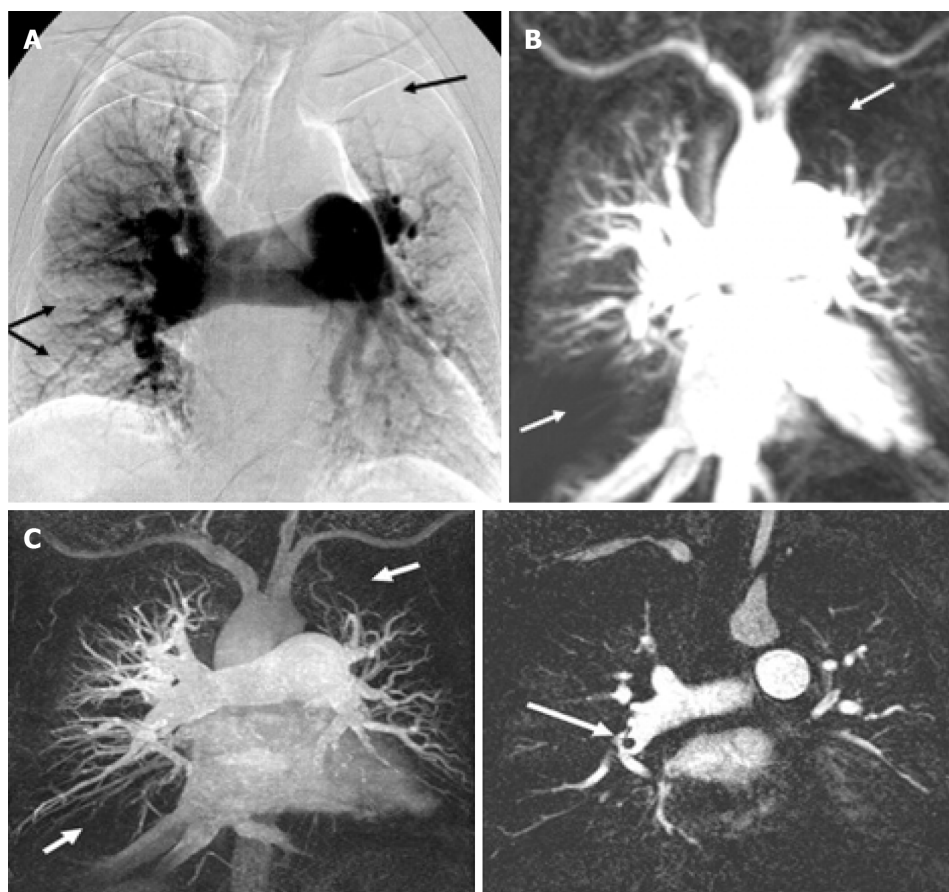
Comparing digital subtraction angiography, pulmonary perfusion magnetic resonance imaging and magnetic resonance angiography for identifying perfusion defects in chronic thromboembolic pulmonary hypertension patient. A: Digital subtraction angiography showing perfusion defects (arrows) in left upper lobe and right lower lobe due to thromboembolic occlusion; B: Magnetic resonance imaging perfusion image at peak enhancement showing hypo-intense perfusion defects at same locations; C: Magnetic resonance angiogram of the same patient demonstrating dark thromboembolic material in the right pulmonary artery corresponding to perfusion defects at the same location. Citation: Nikolaou K, Schoenberg SO, Attenberger U, Scheidler J, Dietrich O, Kuehn B, Rosa F, Huber A, Leuchte H, Baumgartner R, Behr J, Reiser MF. Pulmonary arterial hypertension: diagnosis with fast perfusion MR imaging and high-spatial-resolution MR angiography—preliminary experience. *Radiology* 2005; 236: 694-703 [PMID: 15994997 DOI: 10.1148/radiol.2361040502].
